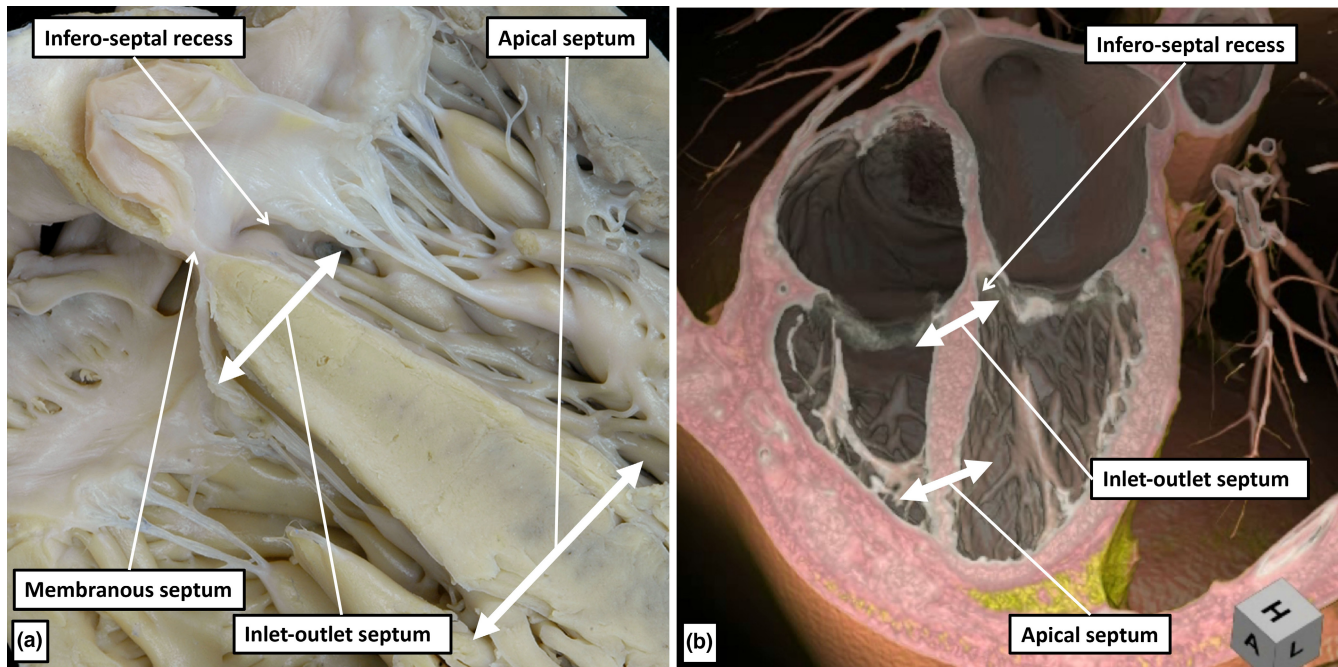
(a) Is a four-chamber section through the interleaflet triangle separating the non-coronary and right coronary sinuses of the aortic root. It shows the small size of the membranous parts of the ventricular septum. By virtue of the wedging the aortic root between the mitral valve and the septum, the section also shows how the inferior part of the muscular septum interposes between the inlet of the right and the outlet of the left ventricles, extending apically to separate the apical components. These features are also shown in (b), taken from a clinical computed tomographic dataset prepared to show a normal heart.
